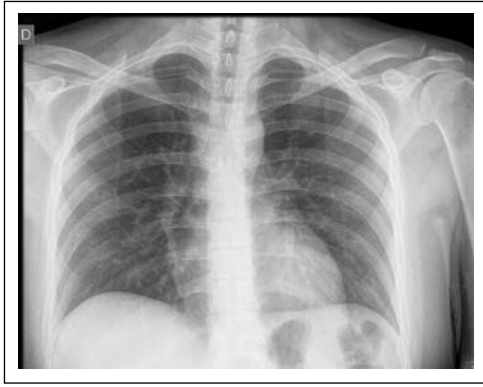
Plain chest X-Ray.
